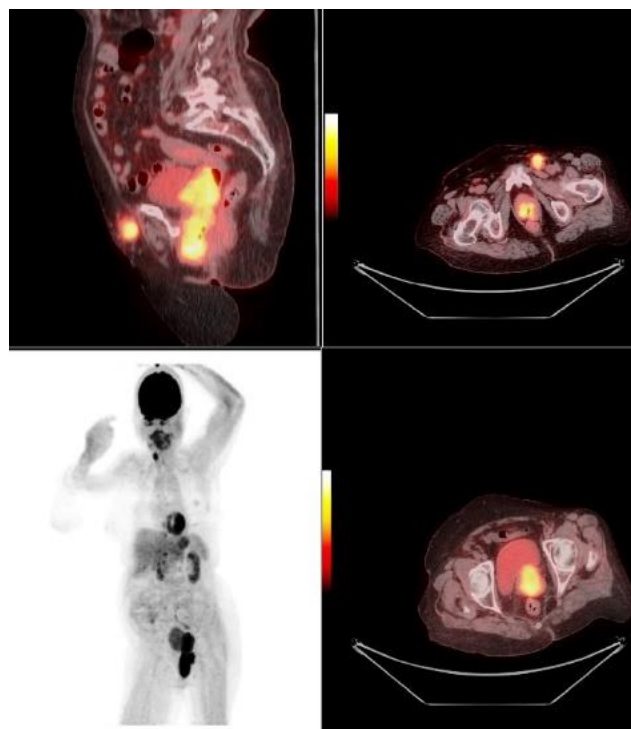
<sup>18</sup>F-FDG PET-CT scan.
